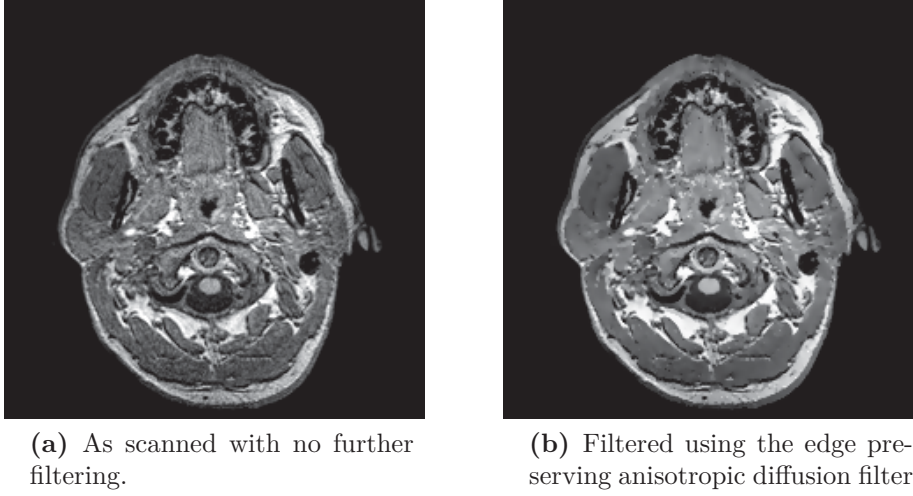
Sample MRI transverse slice highlighting the postprocessing using the edge preserving filter
